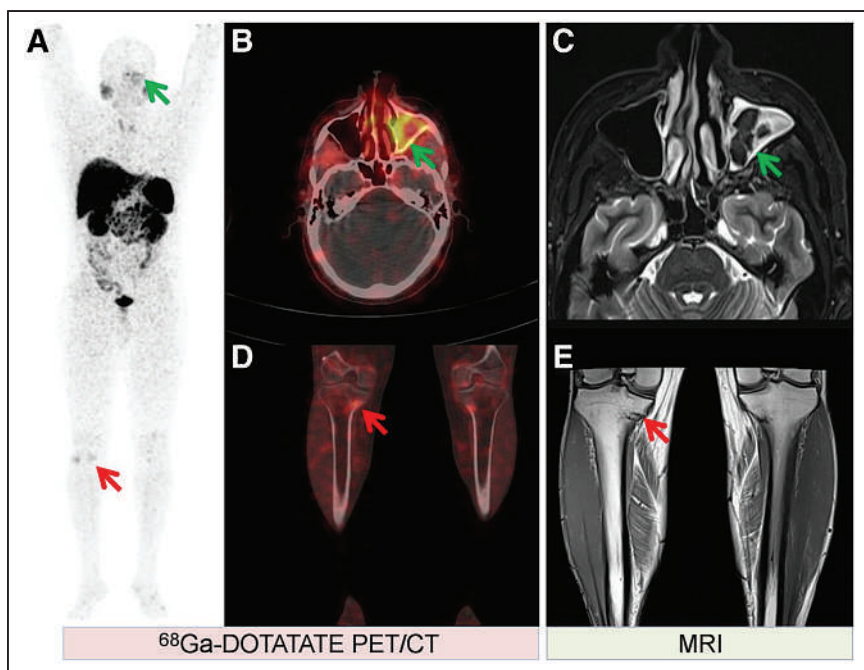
(A) Maximum-intensity-projection ^{68}Ga -DOTATATE PET image showing abnormal SSTR uptake in maxillary sinus (green arrow) and knee (red arrow) regions. (B and D) Transaxial ^{68}Ga -DOTATATE PET/CT image showing mildly increased uptake (arrow, SUV_{max} of 5.42) in left maxillary sinus, with mucosal thickening (B), and coronal ^{68}Ga -DOTATATE PET/CT image showing mildly SSTR-avid sclerotic lesion (arrow, SUV_{max} of 3.84) in medial part of upper condyle of right tibia and faint SSTR uptake in medial part of upper condyle of left tibia (D). (C and E) MRI of maxillary sinus showing moderate T2 hyperintense mucosal thickening in left maxillary sinus, with central T2 hypointense areas due to retained secretion (C, arrow), and MRI with T1-weighted coronal view of knee showing fracture along proximal inner medial part of left and right tibiae (E, arrow), both of which were suggestive of benign etiologies.
